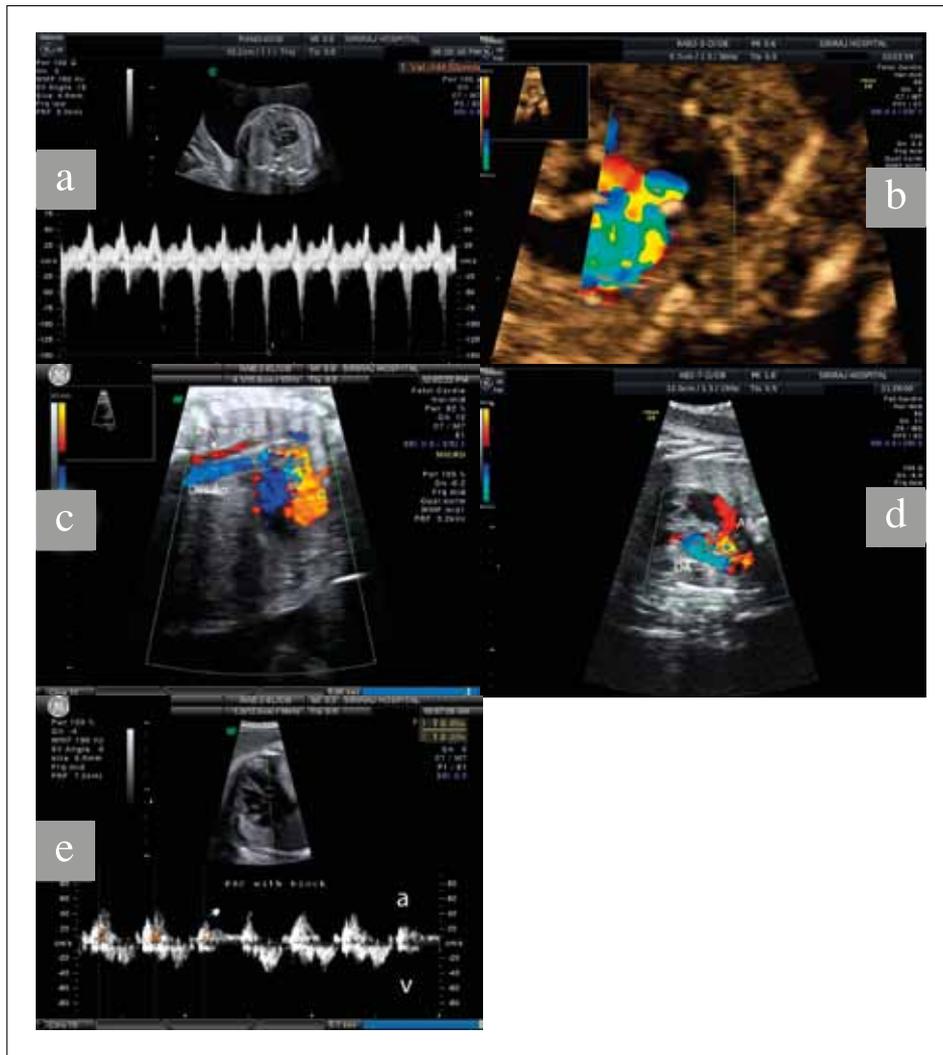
Examples of abnormal Doppler ultrasound findings.
